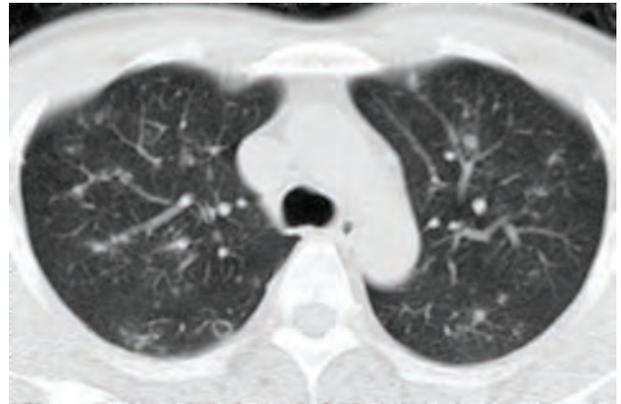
Chest CT scans before smoking cessation.
